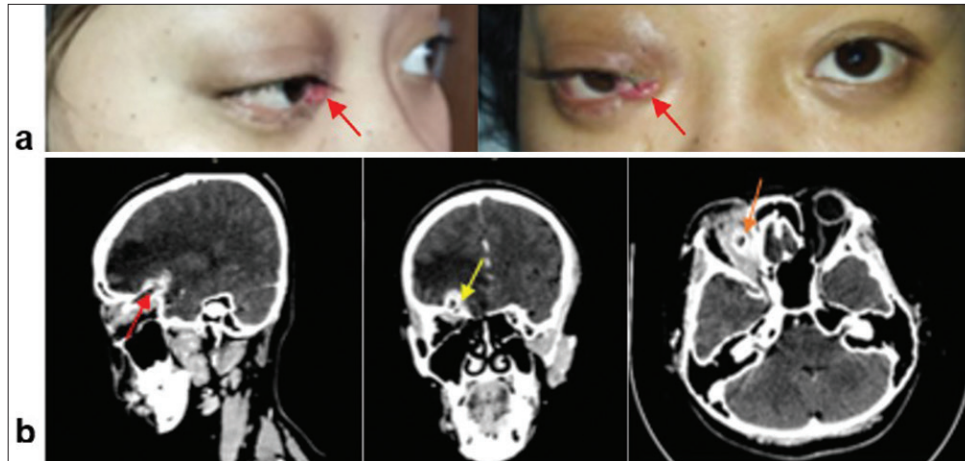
Clinical appearance and imaging of the patient at the time of injury. (a) The red arrows indicate the clinical appearance of the patient's eye at the initial visit; (b) Non-contrast CT scan of the brain window at the time of injury. The image shows a fracture of the superior orbital wall and pneumocephalus. There is no evidence of a foreign body at this time. Red and yellow arrows indicate the fracture of the superior orbital wall and pneumocephalus; (c) CT scan with a bone window. Red and yellow arrows indicate the fracture of the superior orbital wall and pneumocephalus.
